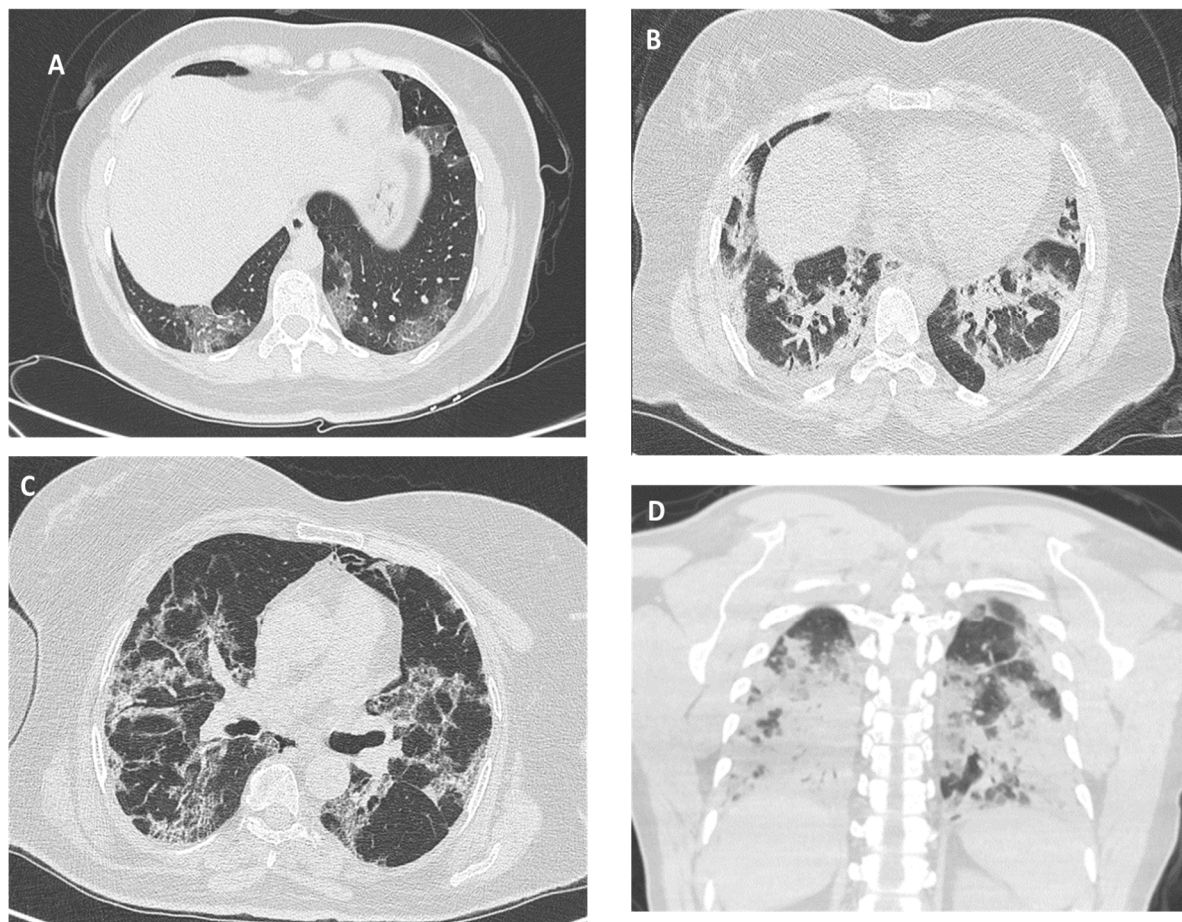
CT of chest lungs window of patients infected with COVID-19. A: An axial CT of the lung in 34 years old female patient with 7 days duration. There was GGO in posterior peripheral lung. B: Axial CT scan lung window of 48 years old female patient with 14 days duration. There was confluent consolidation in the periphery of both lungs, with irregular shape and retractive configuration. C: An axial lung CT of the chest of 62 years old female patient of 20 days duration. there is bilateral mainly peripheral and some central and anterior located GGO with irregular shape, subpleural and interstitial lines seen, mild bronchiectasis in right side. D: Coronal lung section of HRCT of chest of 40 years old male patient with 10 days duration of disease. The consolidation opacities are continuous and extensive in posterior periphery of the lung with basal and midlung predominance and mild apex involvement.
